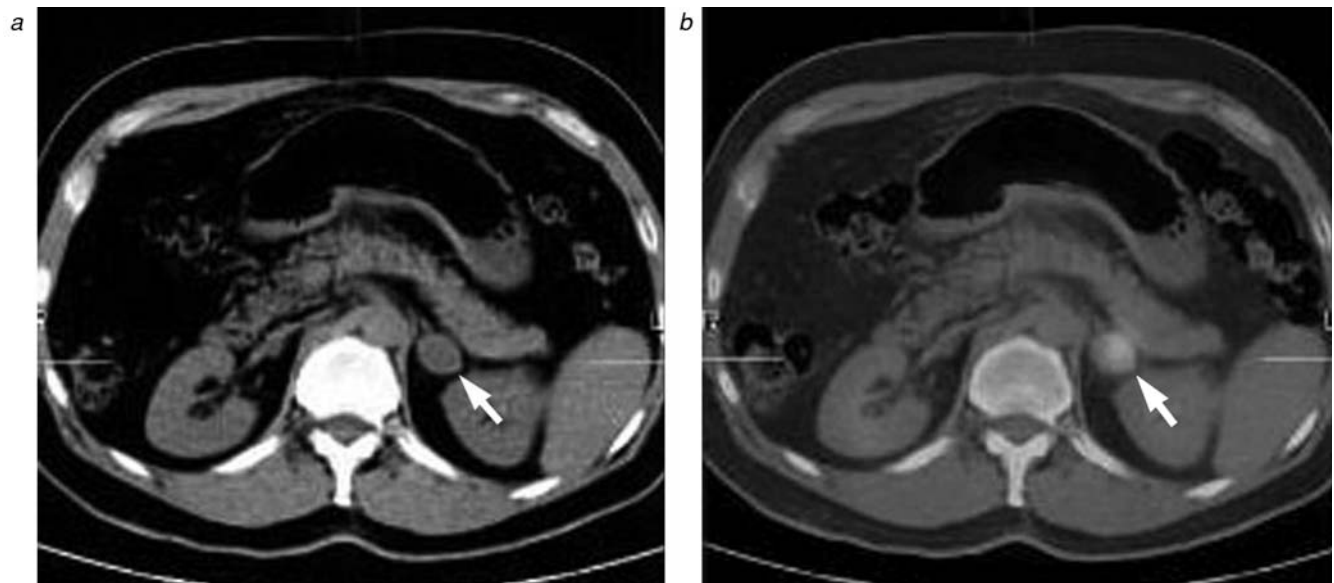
Shown are (a) computed tomography and (b) positron emission tomography images of a metastasis to the left adrenal gland (arrows).
